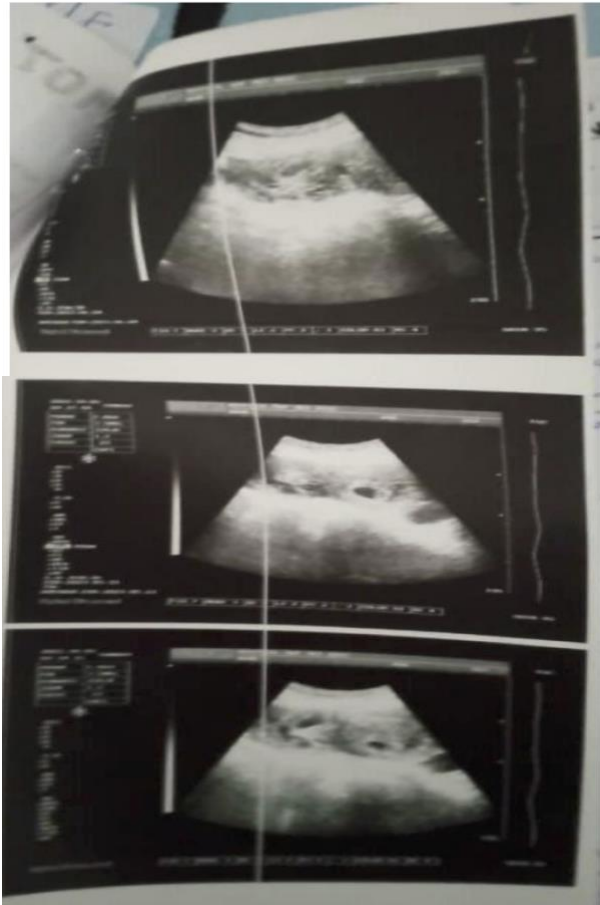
ultrasound scan suggestive of heterotopic pregnancy.
